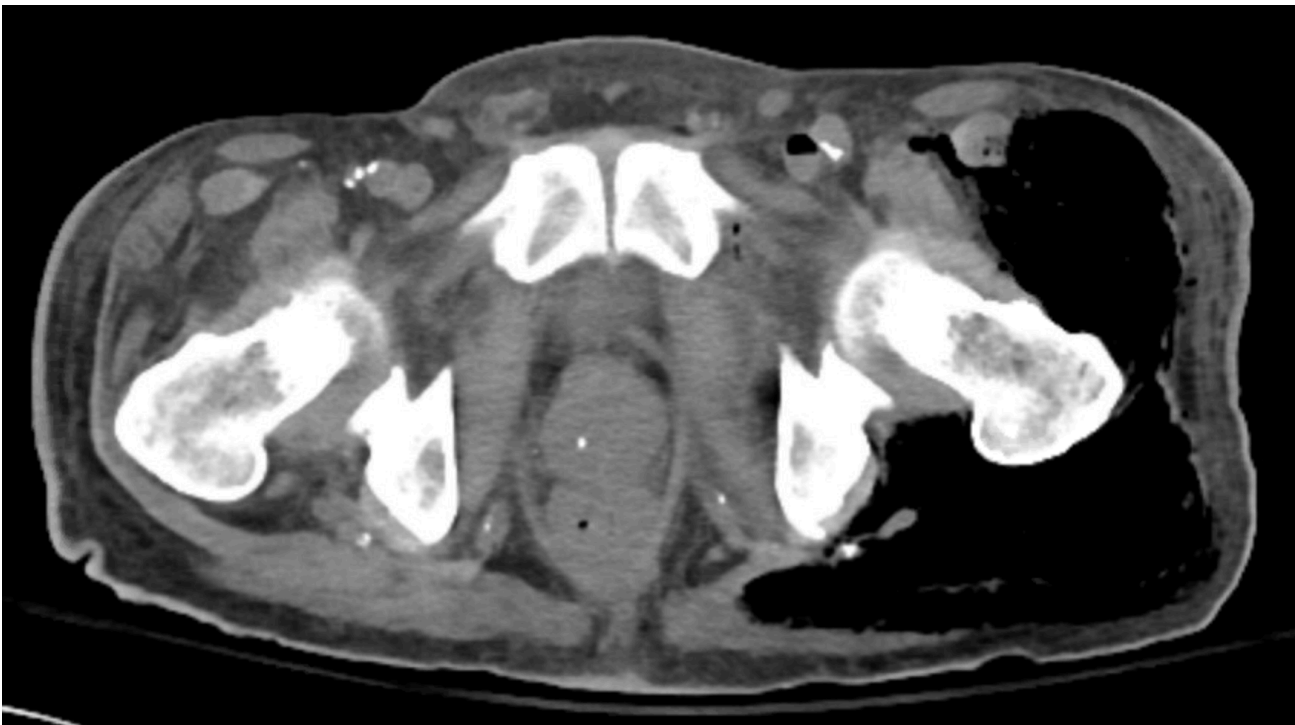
CT scans of the bilateral lower extremities revealed extensive soft tissue emphysema within the left gluteal muscles and the anterior and posterior margins of the proximal left lower extremity.
